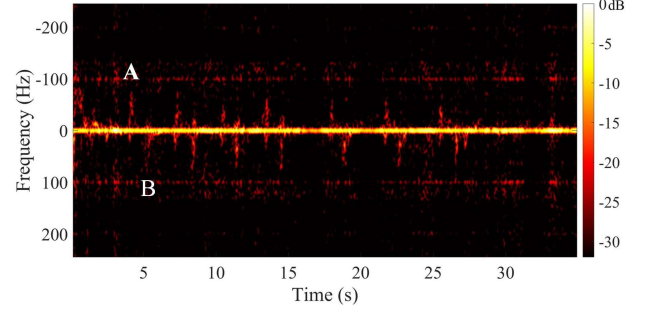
Extracted micro-Doppler spectrogram associated with the seven push-ups done by P2.
